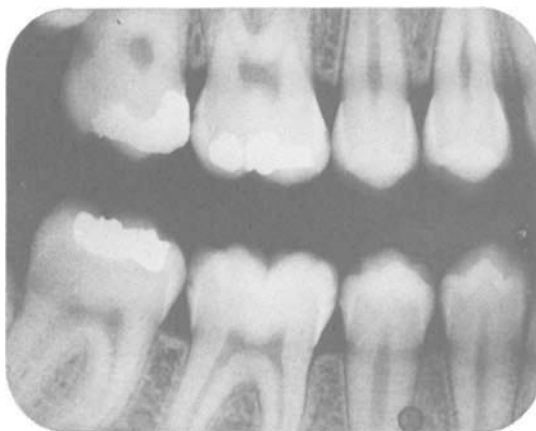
Bitewing radiograph showing incipient enamel caries in the proximal surfaces of the first molars.
